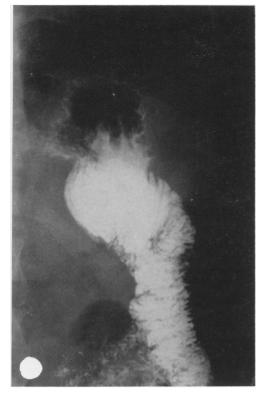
(Case 6) Left: Preoperative x-rays showing poor filling of the afferent loop.
